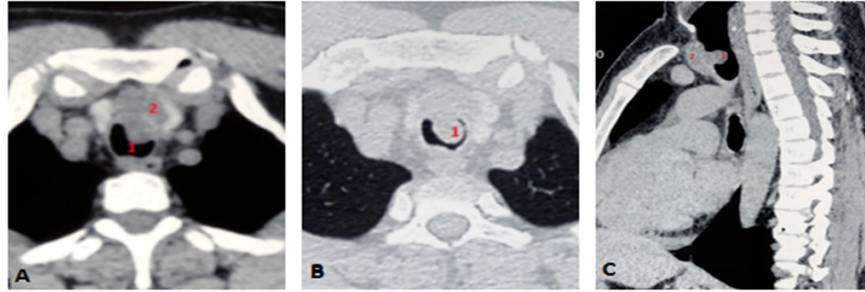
Computed Tomography A) Axial view with 1) intraluminal polypoidal mass 2) extraluminal component of the mass B) Mediastinal Window showing the intraluminal mass occluding 75% of the tracheal lumen C) Sagittal view
